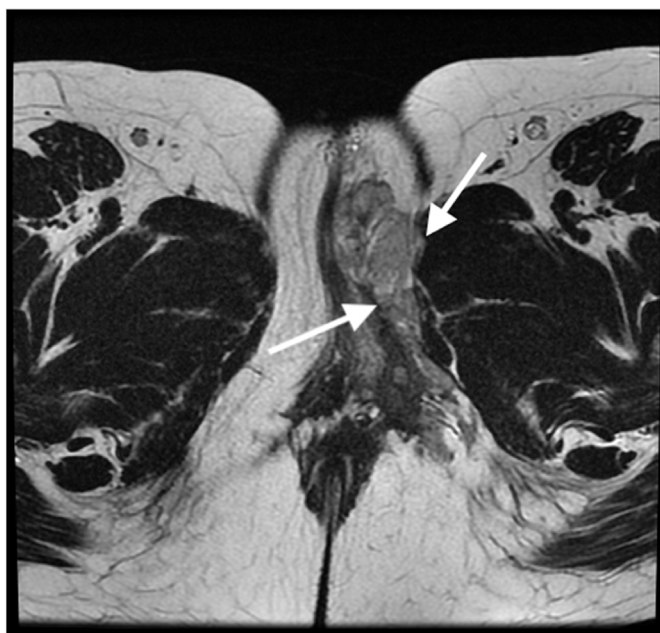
Magnetic resonance imaging of the pelvis (arrows indicate the tumor).
